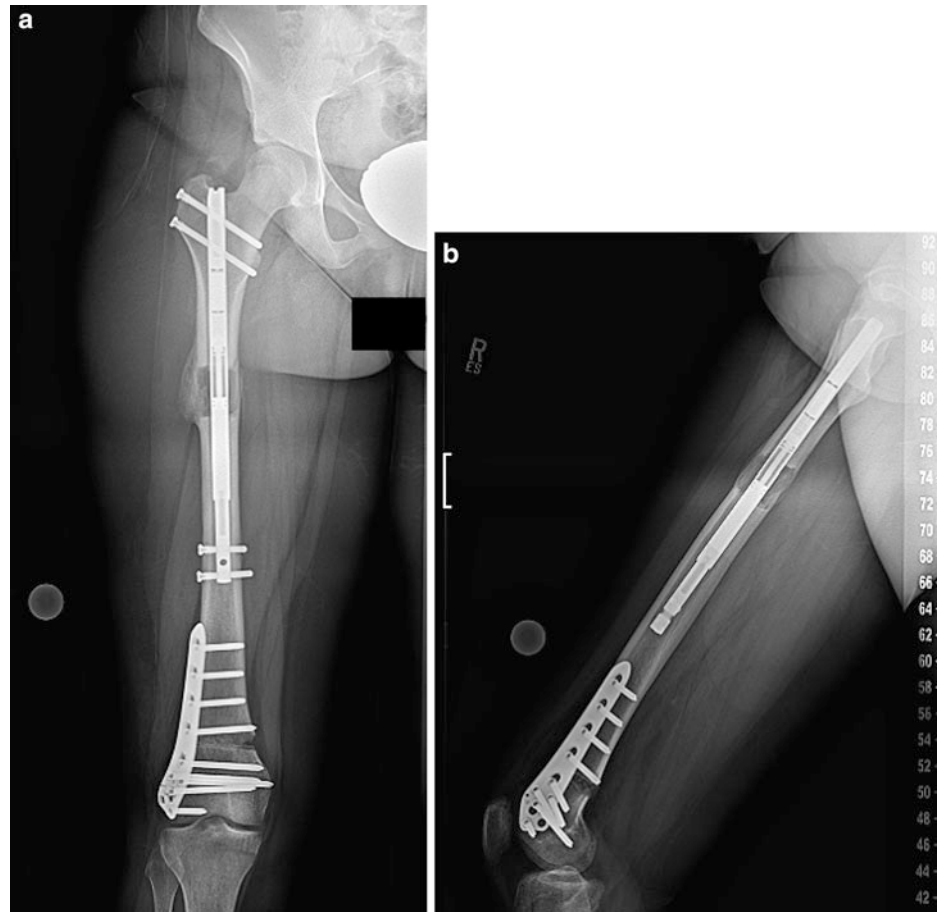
Final X-rays show healing at both osteotomy sites 4 months post surgery (a and b)
